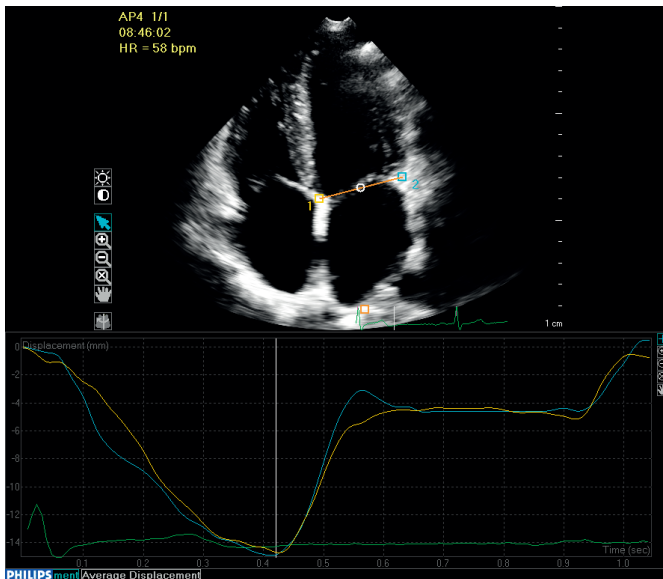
Mitral annular displacement by speckle tracking in apical 4 chambers view. The “apical” fixed point is situated at the bottom of the left atrium.
